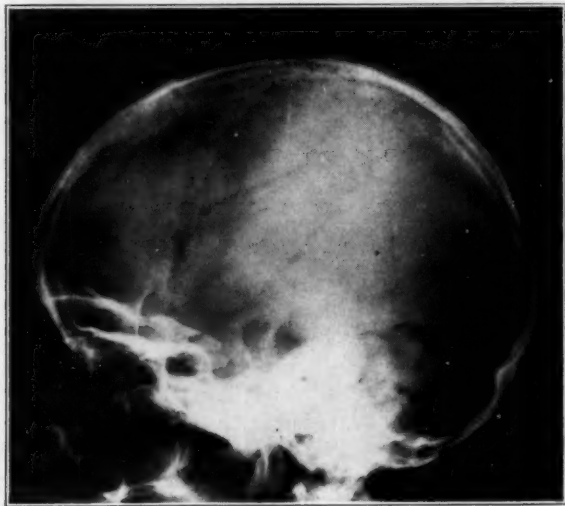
(case 3).—Roentgenogram of the skull, showing the depressed sella turcica with thinning of the dorsum and posterior clinoids.
